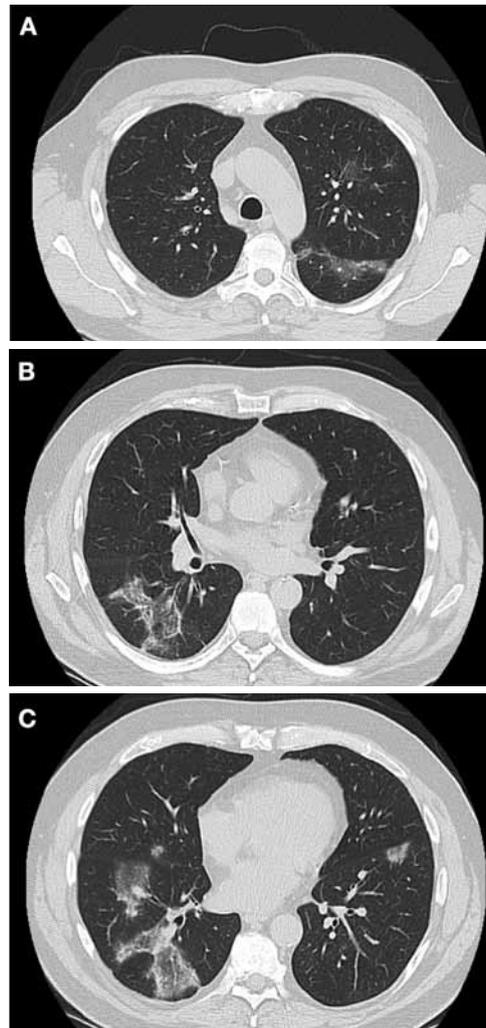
Transverse axial CT images of the patient's chest from November 2017 showing nonspecific patchy areas of mixed airspace (A) and ground glass opacity in the right lung (B), and ground glass opacity in the left upper lobe (C).
